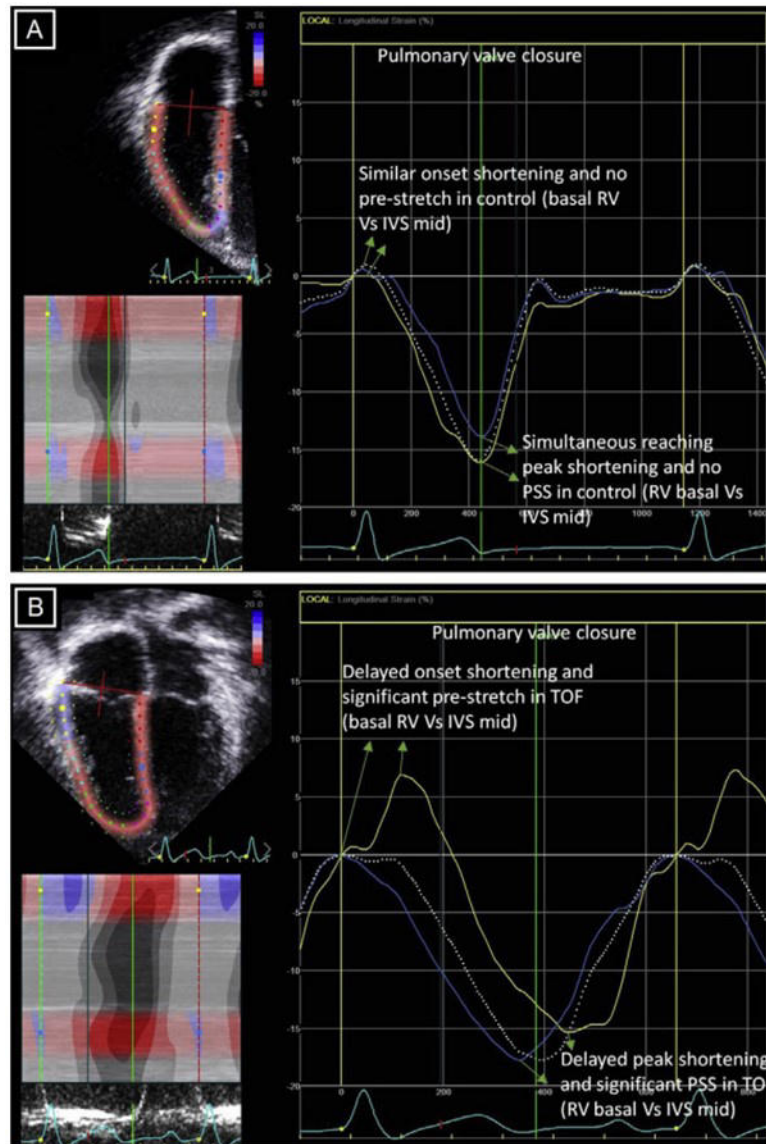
RV segmental strain curves using echocardiographic speckle-tracking showing examples of a control subject A: and a patient after TOF repair. B: Strain curves in the control subject are synchronous with no significant differences in time between basal lateral (yellow curve) and midseptal (blue curve) segments. By comparison, it can be noted that the patient after TOF repair shows early septal activation with prestretch and late contraction post systolic stretch (PSS) of the RV basal lateral segment (yellow curve). The dotted white curve represents the average strain of six RV segments, which is automatically provided by the software. From Yim et al[146].
